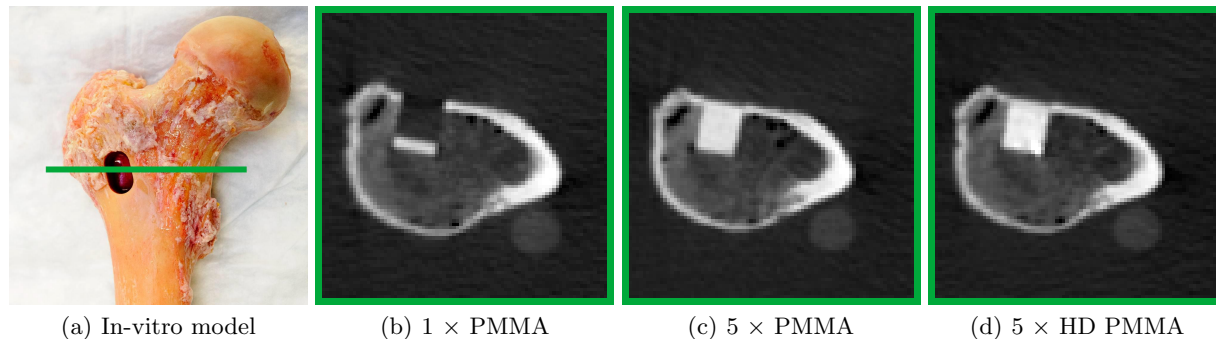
Overview of the in-vitro lesion model. (a) Shows a photo of the milled hole in the intertrochanteric region of the femur, with the line indication the location of the CT images in (b), (c) and (d). (b) Shows a single plate of PMMA in a water-filled hole. (c) Shows a intersection of the transversal CT slice with five PMMA plates, whereas (d) contains five HD-PMMA plates.
